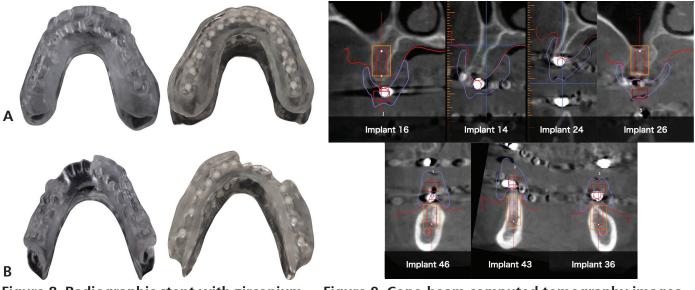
Radiographic stent with zirconium pearls. (A) Maxilla; (B) mandible.
